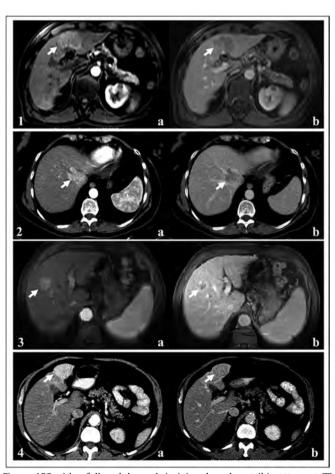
ICC with a full-nodule wash-in (a) and wash-out (b) pattern at CT or MRI contrast-enhanced imaging, mimicking typical features of HCC.
